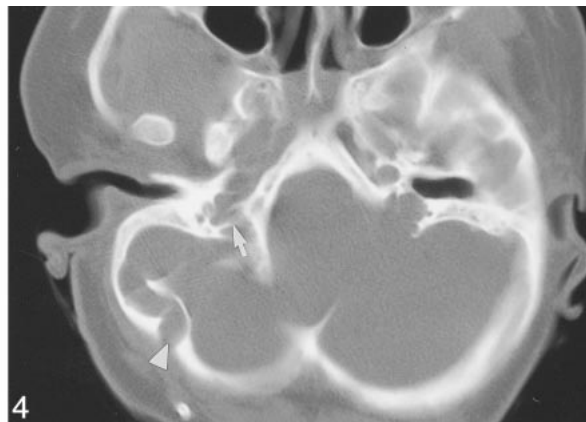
Case 20: Ten-year-old girl with Pfeiffer syndrome and FGFR2 ser354cys mutation. Helical CT shows a large right occipitomastoid emissary foramen (*arrowhead*). The right jugular foramen is stenotic, with prominent septations (*arrow*). The left JF appeared stenotic on a caudal image of the skull base (not shown).
